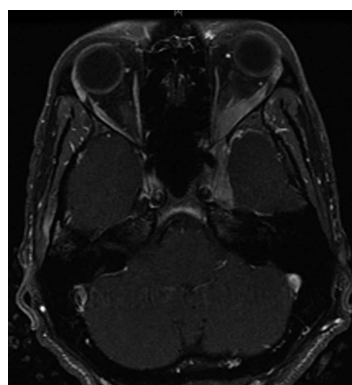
Brain magnetic resonance imaging with gadolinium showing diffuse thickening and enhancement of the dura involving the left cavernous sinus, with mild mass effect on the left temporal lobe, and soft tissue enhancement extending anteriorly through the foramen rotundum and left orbital apex.
